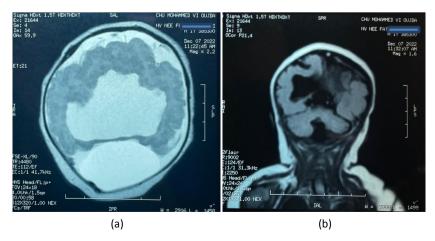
(a & b) MRI axial and coronal sections showing: dilation of a single ventricular cavity with absence of inter hemispheric fissure.
